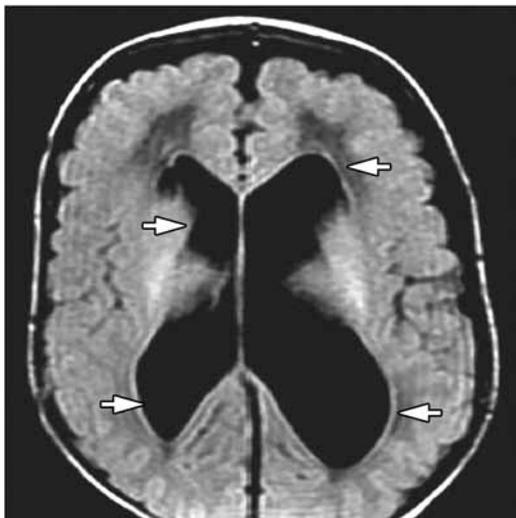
Brain MRI at 4 months of age showing leukomalacia and mild enlargement of both lateral ventricles, most likely secondary to intraventricular hemorrhage.
